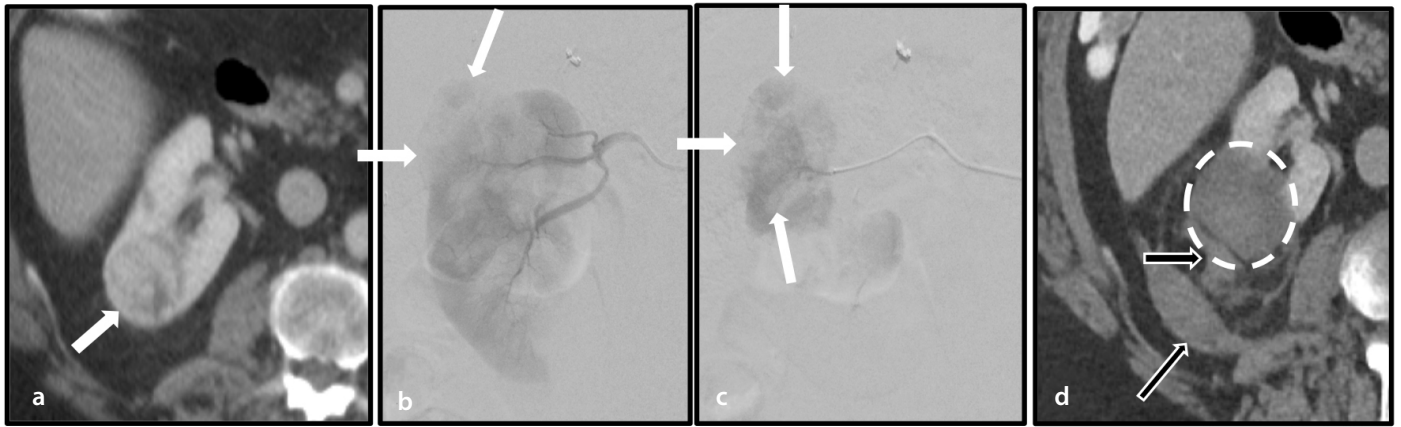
(a) A right upper pole renal cell carcinoma (white arrows) demonstrates abnormal tortuous intra-tumoral vessels on angiography (b) during pre-ablation renal artery embolization (b, c). Post-ablation contrast-enhanced CT (d) demonstrates a hypoattenuating ablation zone without residual enhancement (white circle). A small amount of posterior perirenal hemorrhage is present (black arrows). CT, computed tomography.
